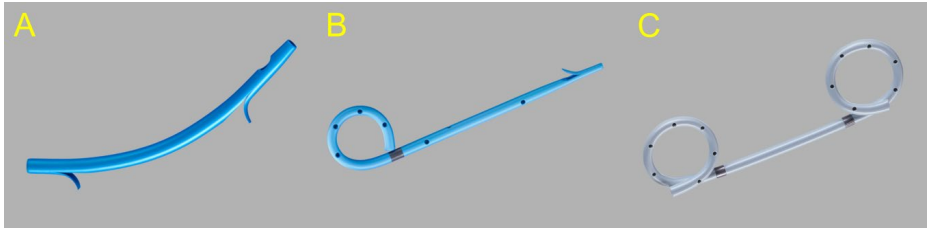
Plastic stents are made of polyethylene or Teflon and are available in varying size, shapes and length for endoscopic ultrasound-guided drainage (A) Straight “Amsterdam” type stent. (B) Double pigtail configurations help anchor the stent to prevent bidirectional migration. (C) Single pigtail configurations help anchor the stent to prevent inward migration.
